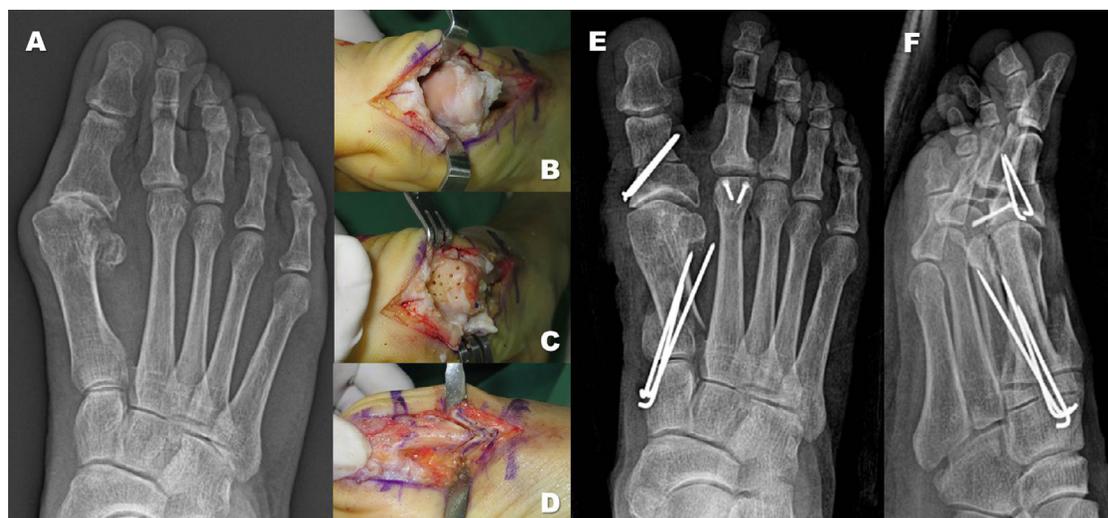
A female, aged 58 years, with a hallux valgus deformity with advanced arthritic change of the first metatarsophalangeal joint (A). Cartilage denuding of the metatarsal head was noted intraoperatively (B). After removing the medial eminence, we performed multiple drilling with a 0.9-mm Kirschner wire (C). Double chevron osteotomies of the proximal metatarsal were performed (D). The immediate postoperative radiographs showed shortening (E) and lowering (F) of the metatarsal bone.
